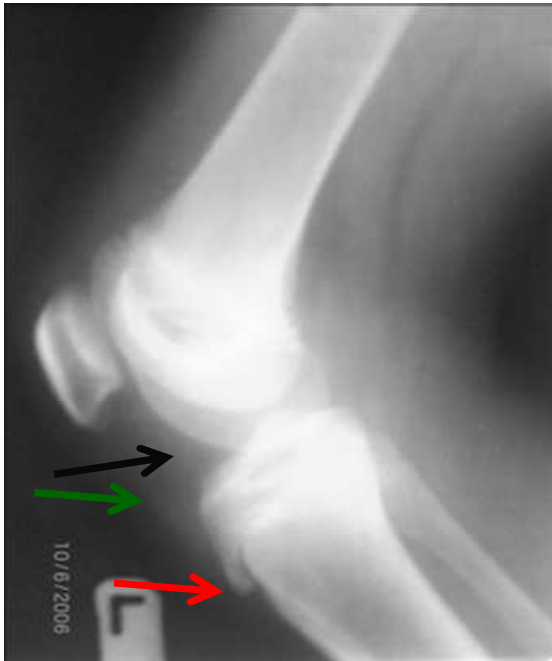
Plain radiograph of the left knee joint showing soft tissue swelling anterior to the tibial tuberosity (red arrow) and indistinct patellar tendon (green arrow)
